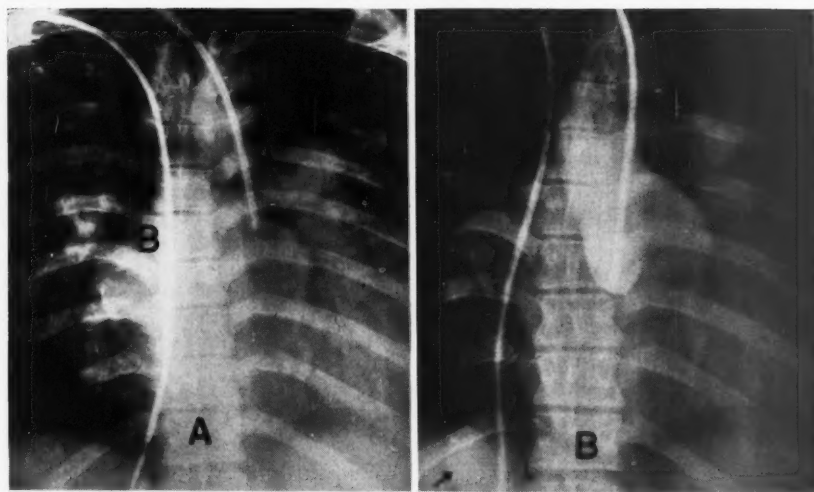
Left.* X-ray scout film showing retrograde aortic catheter tip (A) at base of the aorta. The balloon-tipped catheter (B) has been advanced through the right atrium so that its tip is in the inferior vena cava. *Right.* X-ray taken after retrograde injection of 25 ml. of 70 per cent Diodrast. The balloon occluding the inferior vena cava, containing 30 ml. of approximately 5 per cent Diodrast is faintly shown (small arrows). The aortic valve is competent. The large arrow points to the superior margin of the fistula extending from the right sinus of Valsalva into the right ventricle.
